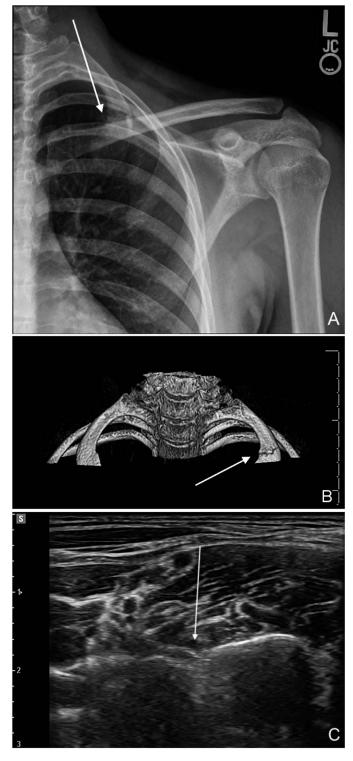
Isolated stress fracture of the left first rib in a 21-year-old female soccer player. A, Shoulder radiograph shows a subtle linear lucency and cortical irregularity at the lateral aspect of the left first rib. B, Noncontrast chest computed tomography with a 3-dimensional reconstructed image demonstrates a nondisplaced stress fracture at the lateral aspect of the left first rib (arrow). C, Bedside ultrasound reveals a cortical irregularity of the first rib (arrow).
